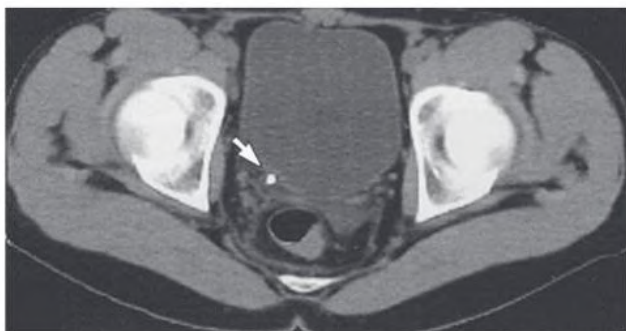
Computed Tomography Scan Demonstrating a Ureteral Calculus. Non-contrast-enhanced scan showing a calculus (arrow) at the right vesicoureteral junction.
